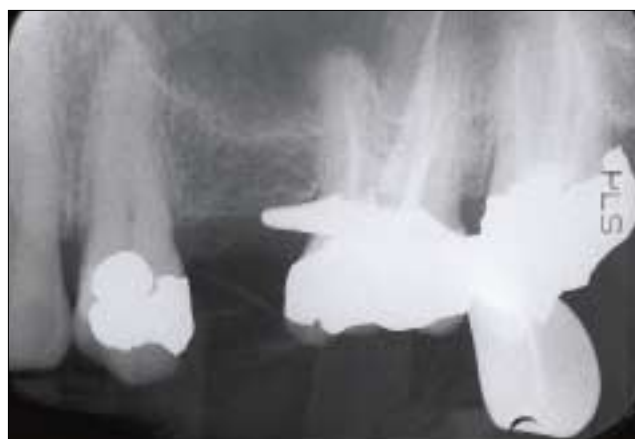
Preoperative radiograph of left maxillary first molar.
